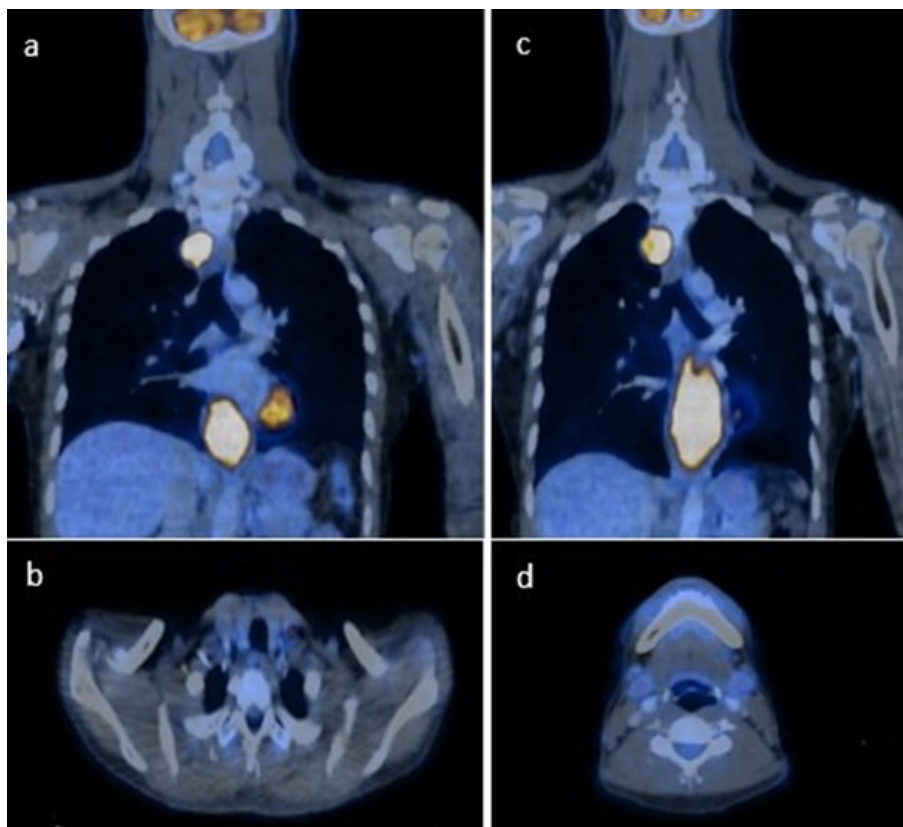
After 2 sessions of immunotherapy, follow-up FDG PET/CT revealed [a] Metabolic progression of the esophageal mass and metabolic regression of the paratracheal lymphadenopathy and; [b] FDG-avid left supraclavicular lymph node. Follow-up FDG PET/CT scan after additional immunotherapy revealed [c] gross and metabolic progression of the esophageal mass and paratracheal lymph node and [d] new FDG-avid cervical lymph nodes.
